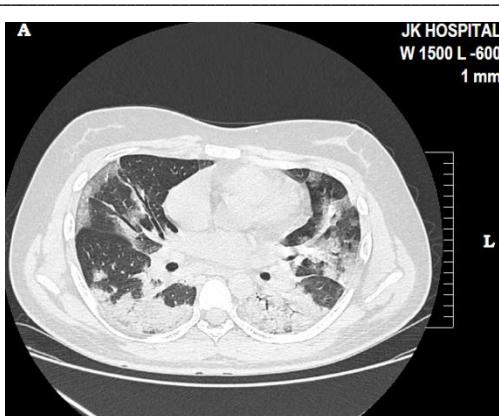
HRCT of young patient under age of 20 year showing multiple discrete and confluent patches of GGO with consolidation and septal thickening giving crazy paving appearance CT severity score; 24-26 (Severe lung involvement).
